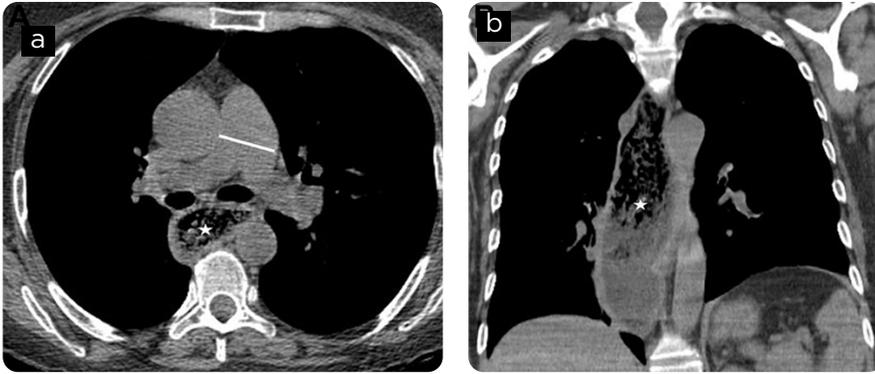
Patient with history of systemic sclerosis. Chest CT, mediastinal window. a) axial section in upper lobes and b) coronal reconstruction. Prominence of the main pulmonary artery due to pulmonary arterial hypertension (white line in a). There is dilatation of the esophagus in its three thirds (asterisk).
